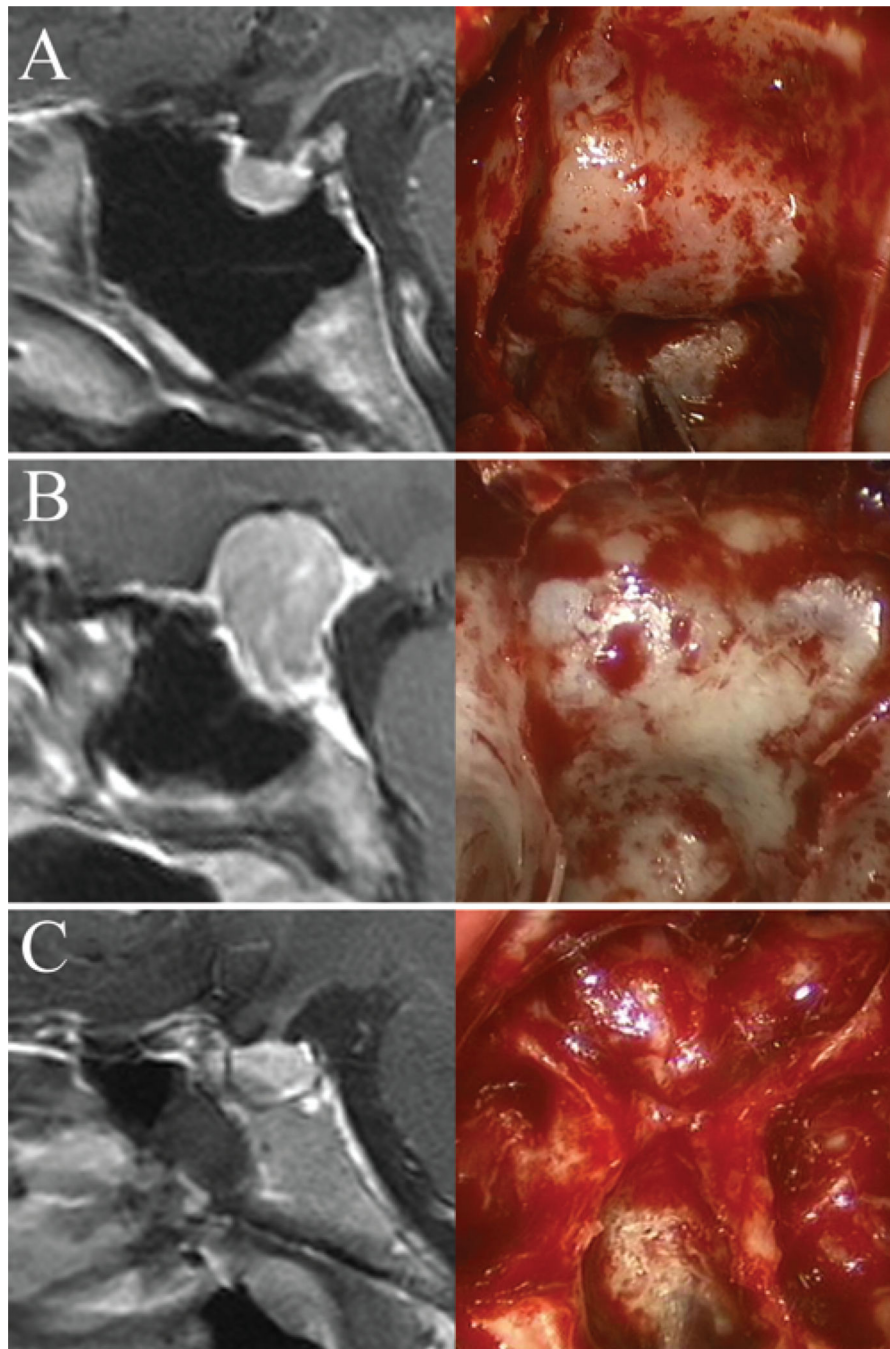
Sagittal MR imaging and intraoperative endoscopic images of the sellar floor and morphology. A: Example of a prominent sella that is easily identifiable intraoperatively. B: Example of an intermediate sellar type. C: Example of a flat sella that is very difficult to differentiate from the clivus. Intraoperative neuronavigation was extremely useful in this case.
